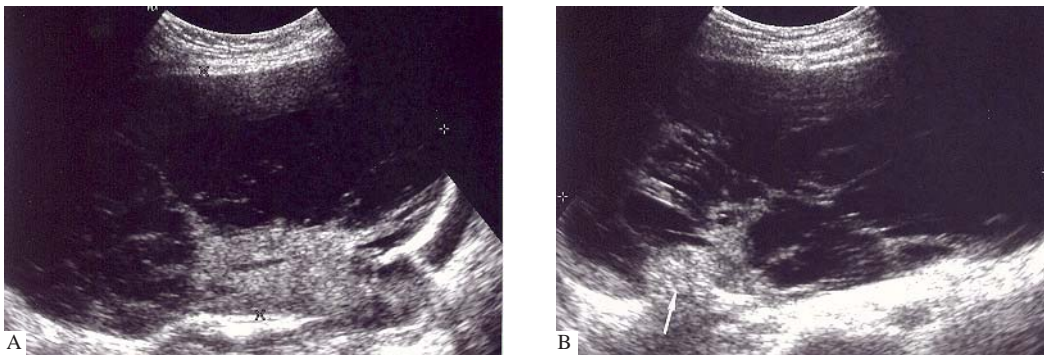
(A). Pelvic sonogram of a 56-year-old post-menopausal woman showing a large and predominantly cystic mass located just above the uterus, with multiple thin internal septations, in the longitudinal plane. (B) In the transverse plane, it shows an irregular solid nodular component (arrow) in the right posterior corner of the mass.
